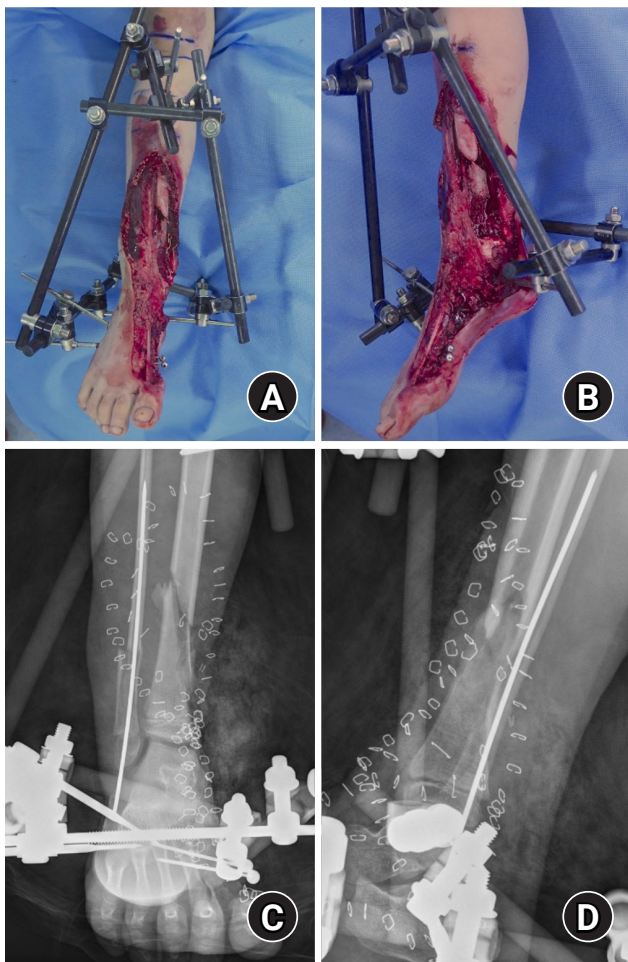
Postdamage control stabilization with external fixation. (A) Anteroposterior gross photograph obtained after initial irrigation and debridement, showing temporary stabilization with an external fixator. (B) Lateral gross photograph obtained after initial irrigation and debridement, demonstrating temporary stabilization with an external fixator. (C) Anteroposterior radiograph obtained after initial irrigation and debridement, showing temporary stabilization with an external fixator. (D) Lateral radiograph obtained after initial irrigation and debridement, demonstrating temporary stabilization with an external fixator.
